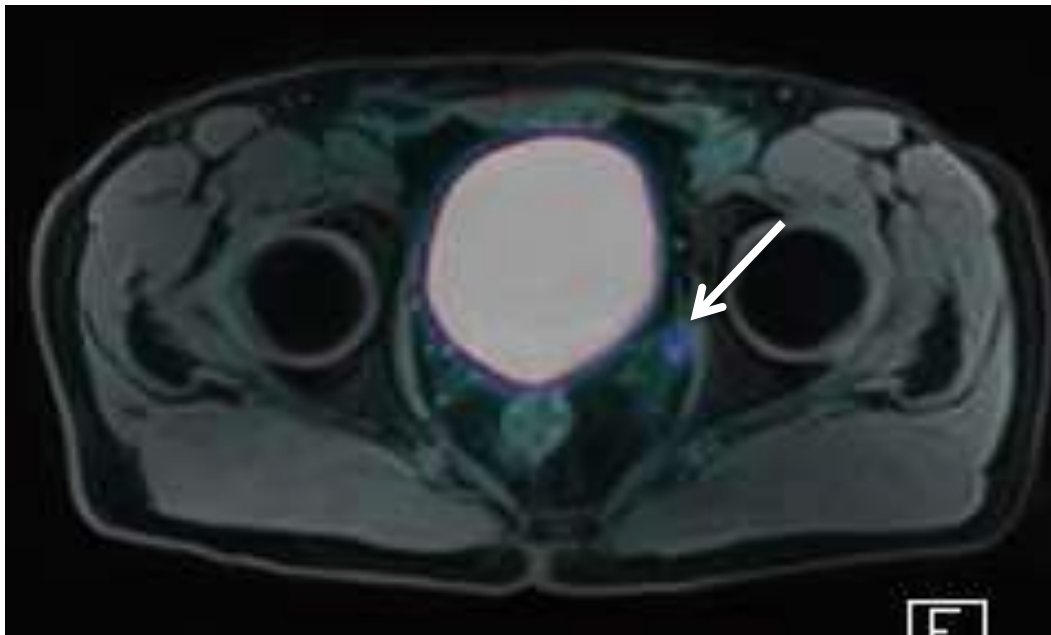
PSMA PET avid Seminal vesical invasive disease identified in patient BCR021; (A) PSMA avid lesion involving the base of right prostate gland transition zone on Dynamic MRI (B) Invasion into right seminal vesicles demonstrated on DWI MRI (white arrows).
